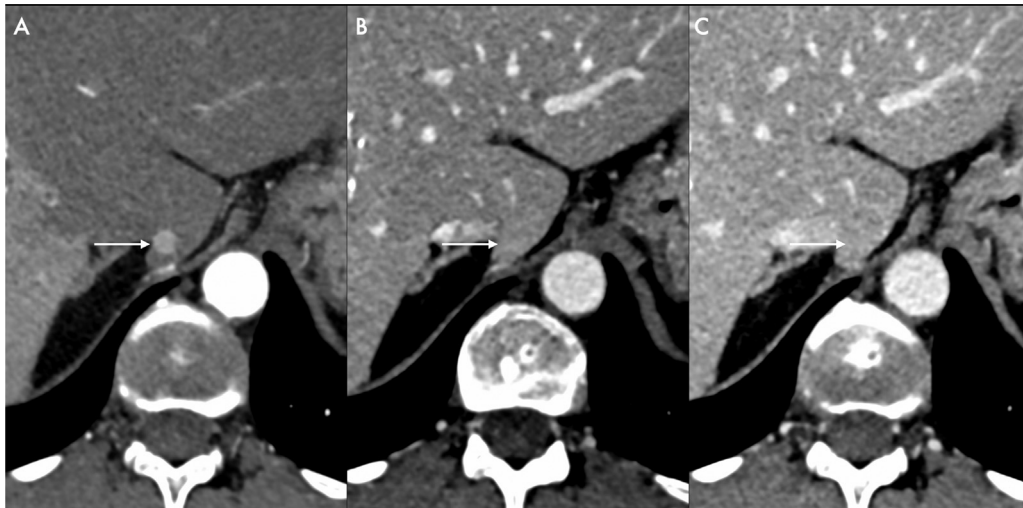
(A–C) LR-3 observation: Contrast-enhanced computed tomography study shows a 5 mm observation (white arrow) in segment I showing nonrim arterial phase hyperenhancement in late arterial phase (A), without showing washout in portal venous phase (B) or enhancing capsule in delayed phase (C).
